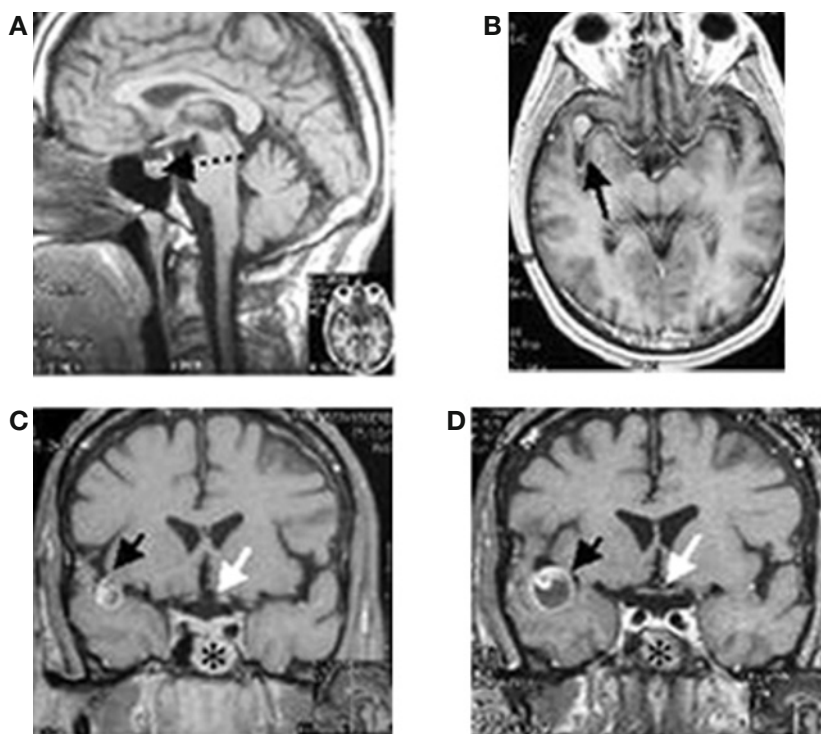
Contrast-enhanced T1-weighted magnetic resonance imaging (MRI) images. A) Pre-operative MRI, Sagittal plane: the anterior portion of the pituitary demonstrates a 9 mm low signal microadenoma (dotted black arrow). B) Pre-operative MRI, Axial plane: showing an aneurysm (11 mm, diameter) of the right medial cerebral artery (MCA) (solid black arrow). C) Post-operative MRI image 6 months after transphenoidal (TS) surgery, showing a normal shape and size of pituitary gland (white arrow) and the aneurysm of the right MCA (black arrow). There is an irregular mass (\*) in the sphenoid sinus related to the packing adipose tissue. D) Post-operative MRI image 2 yr after TS surgery, demonstrating an increased diameter (24 mm) of the aneurysm of the MCA (black arrow).
